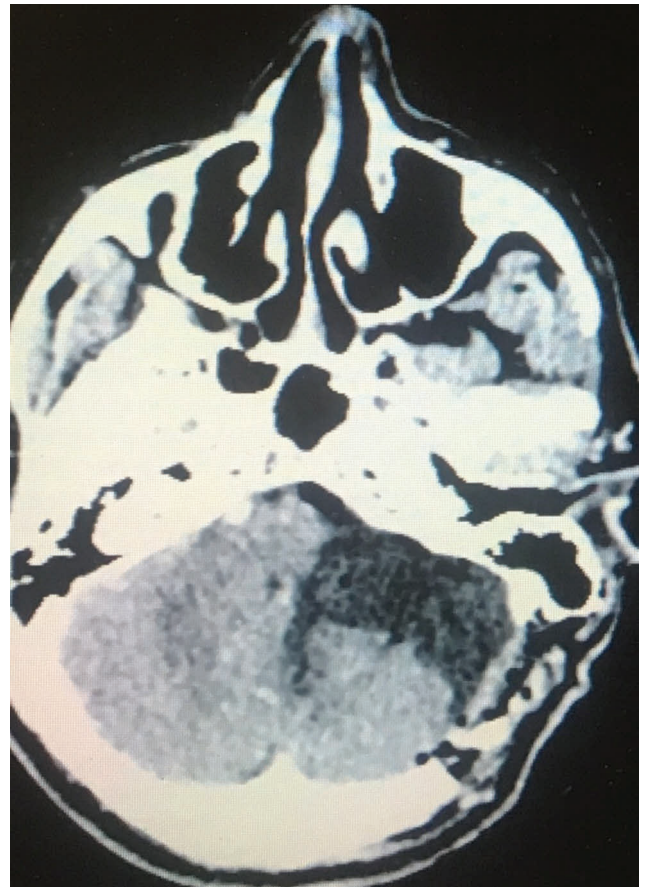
Immediate postoperative CT scan.
